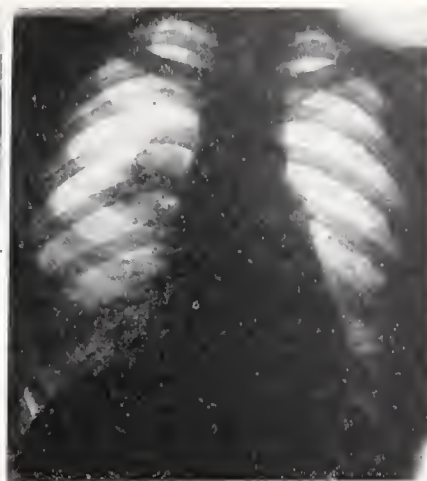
January 9, 1929: X-ray shows a complete compression of the right lung and obliteration of the cavity. The area of cavitation in the right upper lobe appears to be completely closed and fibrosed.
